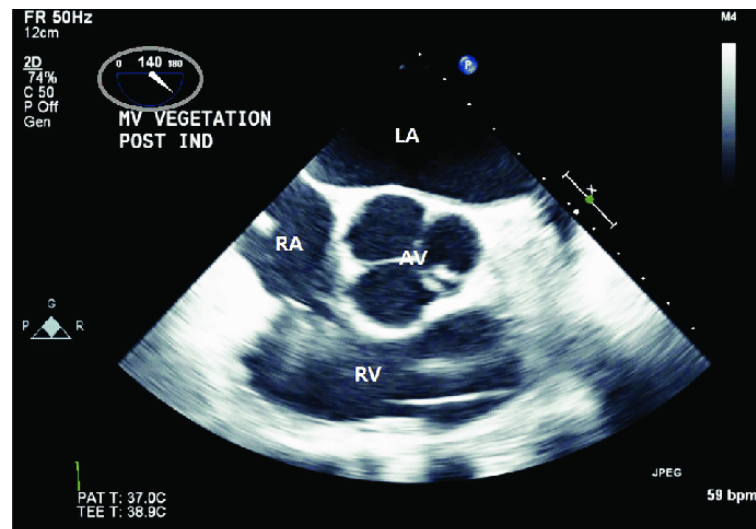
Transesophageal echocardiographic aortic valve short-axis view. AV: aortic valve, LA: left atrium, RA: right atrium, RV: right ventricle [25].
